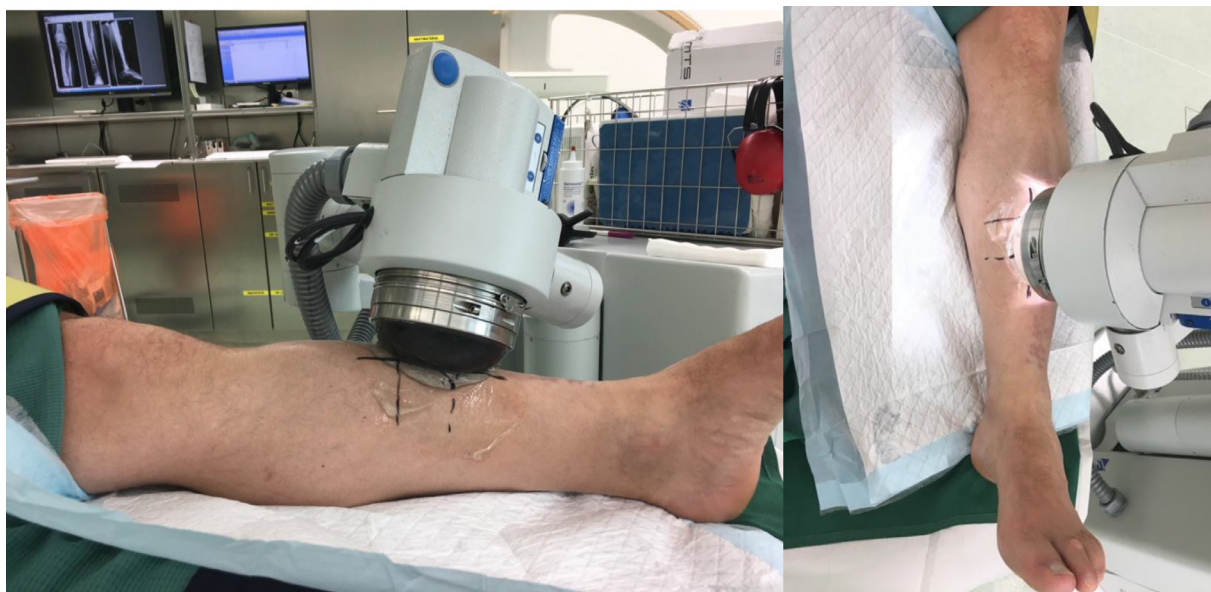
Typical shockwave application of a tibial non-union under general anesthesia in the trauma center Vienna, Meidling. The non-union is located by x-ray fluoroscopy and marked on the skin. Bubble-free conduction gel is applied and the focus of the therapy head is adjusted to the fracture gap. Thereafter, electrohydraulic impulses are applied from different directions.
